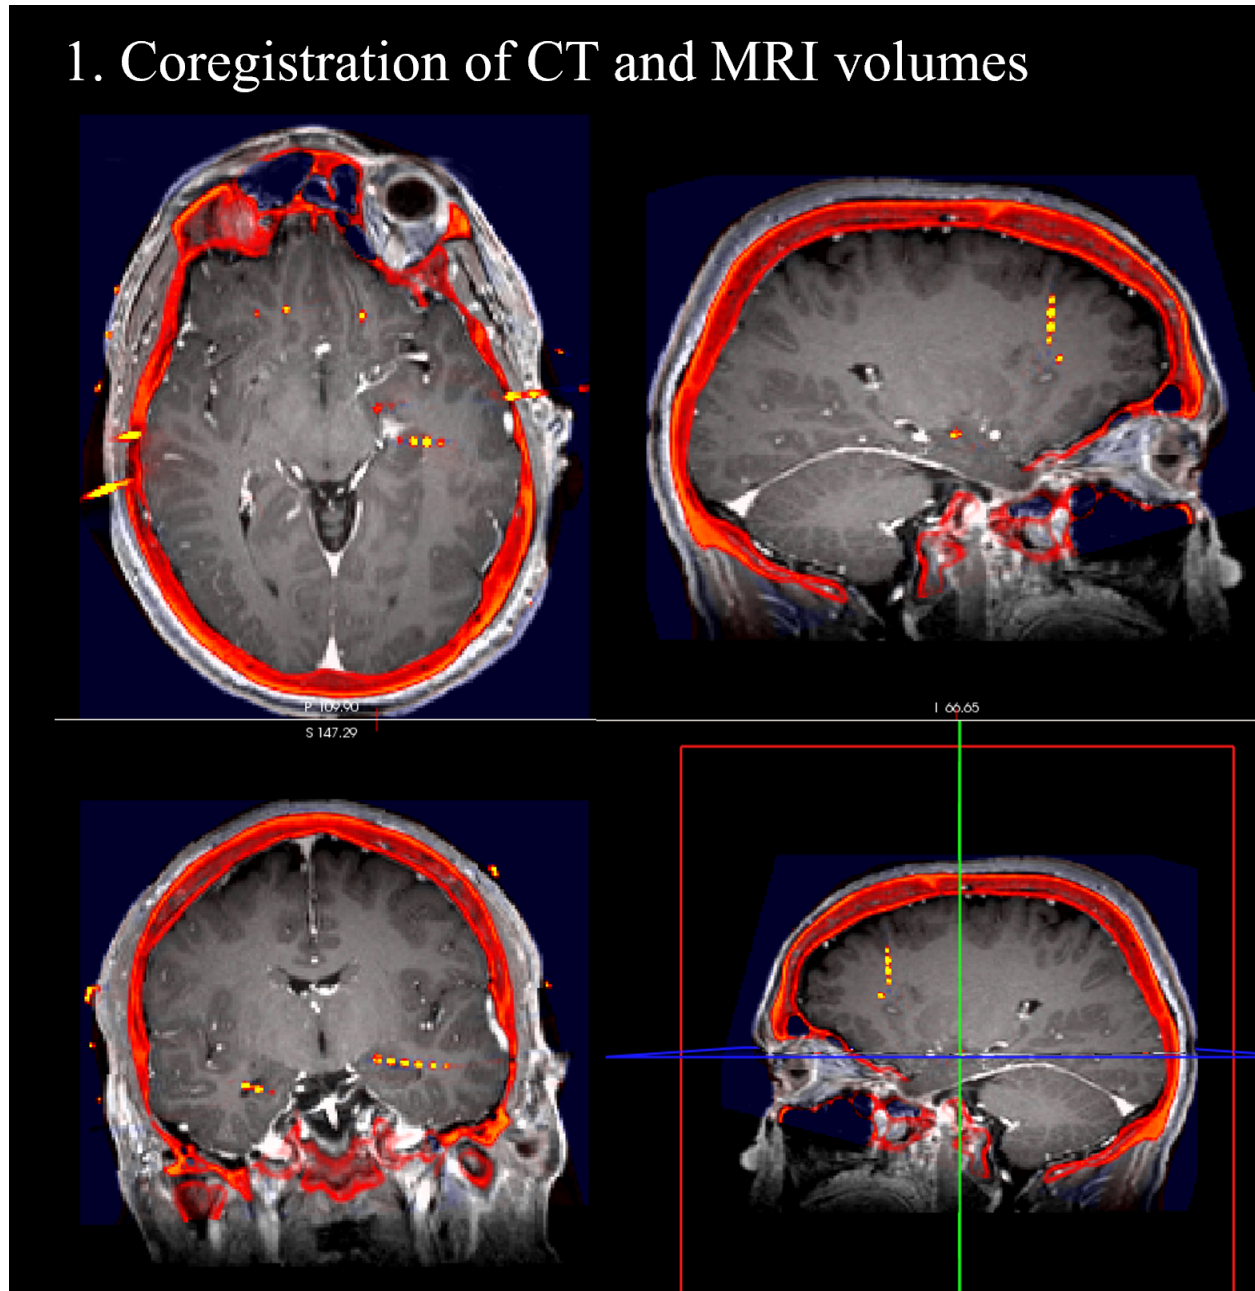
Coregistration output: A patient's CT overlaid on MRI.
